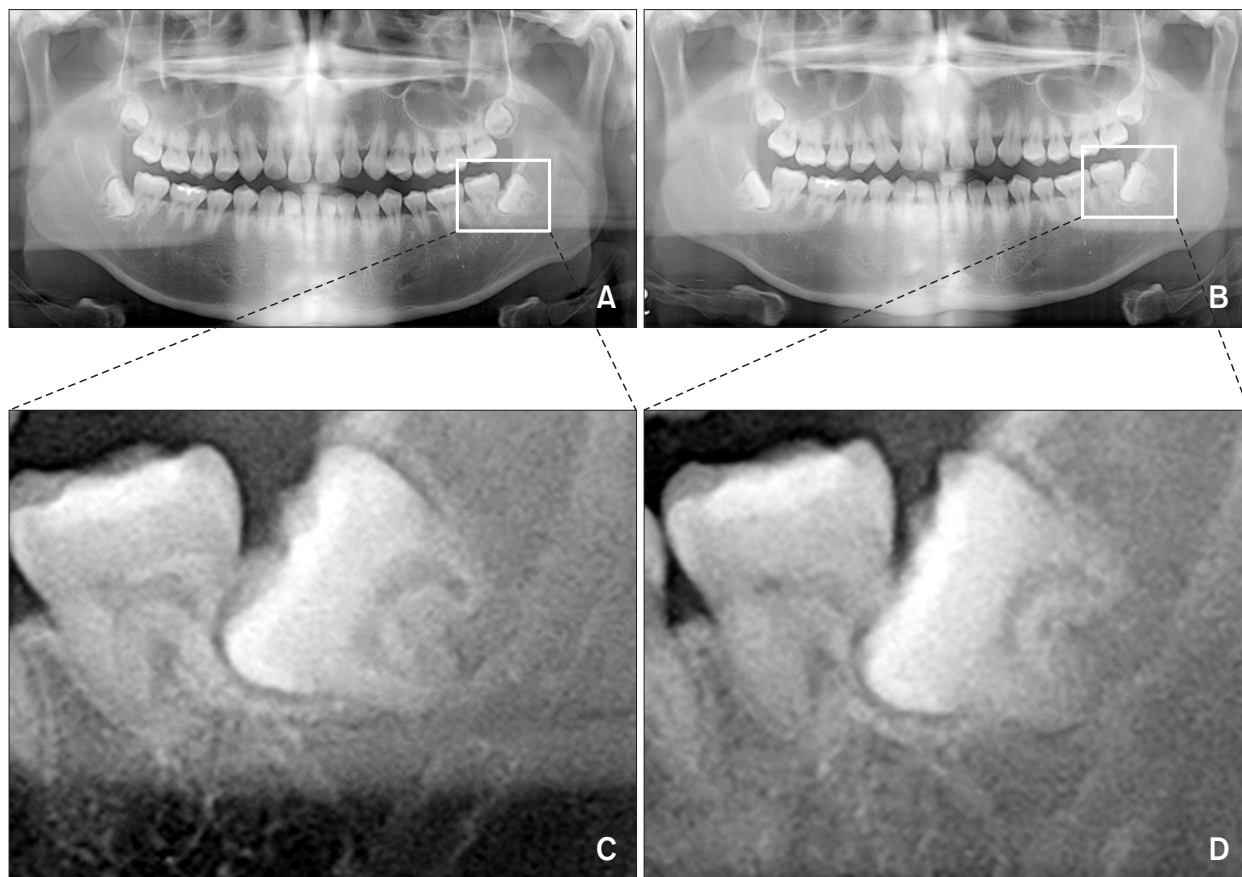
Panoramic radiographs showing the mesially-impacted tooth #38 moving toward the adjacent tooth #37, indicating progressive pressure root resorption of the distal root of tooth #38 over the follow-up period between 2012 (A) and 2014 (B). (C, D) The cropped images showing a magnified view of teeth #37 and #38.
